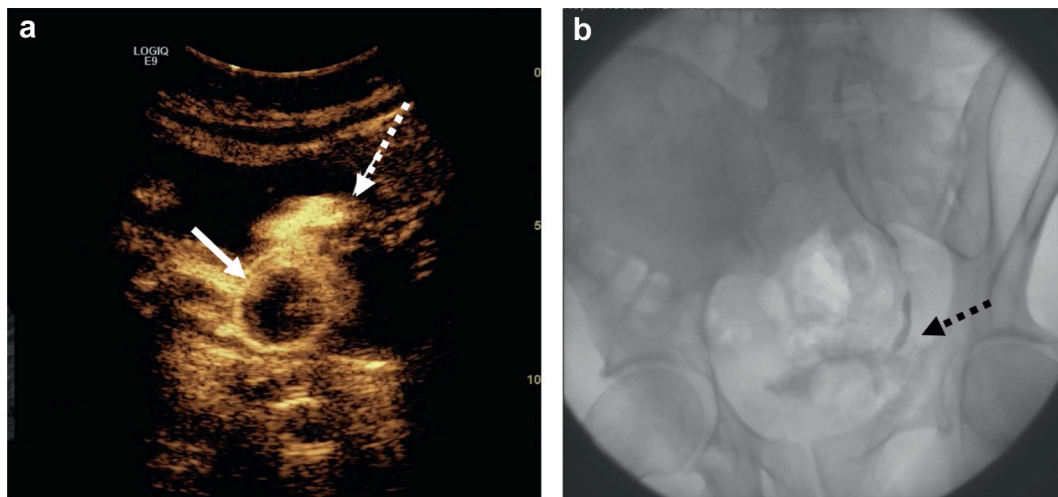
CEUS and fluoroscopic nephrostogram images of 60-year-old male with patent collecting system 1 day after PCNL. *a*, 1 minute after injecting ultrasound contrast agent via preplaced nephrostomy tube CEUS of bladder identified contrast agent in bladder (dashed arrow). Note Foley balloon (solid arrow). *b*, fluoroscopic nephrostogram confirmed ureteral patency and contrast agent entering bladder (dashed arrow).
